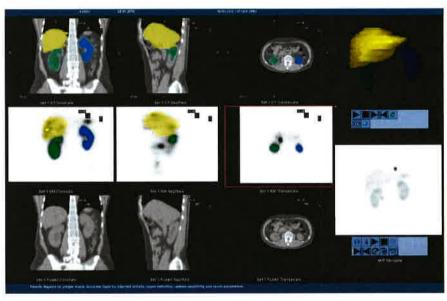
VOI at SPECT/CT GE Xeleris Functional Imaging Workstation
